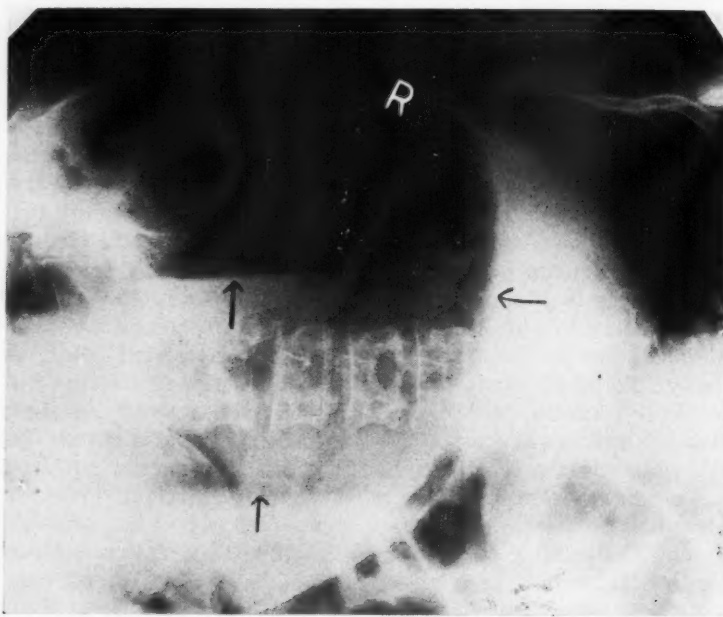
Roentgenogram of abdomen, left lateral decubitus position, same case as Figure 4-A. The enormously distended sigmoid is shown with two fluid levels (arrows) visible because of the position in which the film was made.
